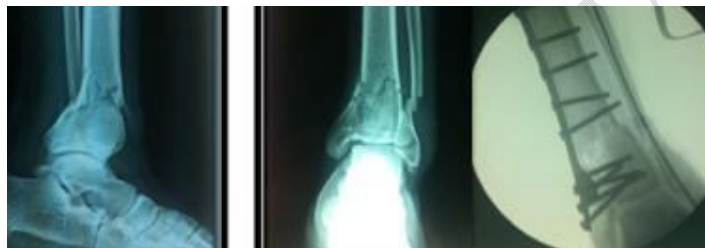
X-ray of the ankle face and profile showing (Ankle AP and lateral) a complex fracture of the tibial pilon treated with a trefoil plate with pinning of the fibula.
